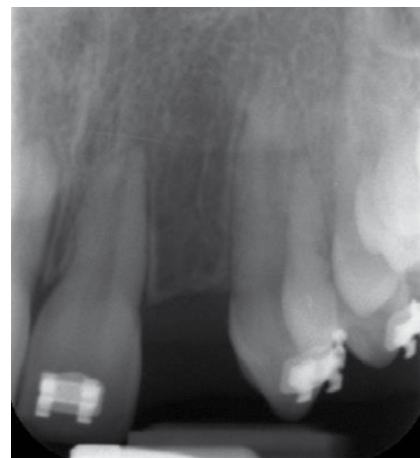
Periapical radiograph prior to debonding to check for sufficient interradicular space and root parallelism.
